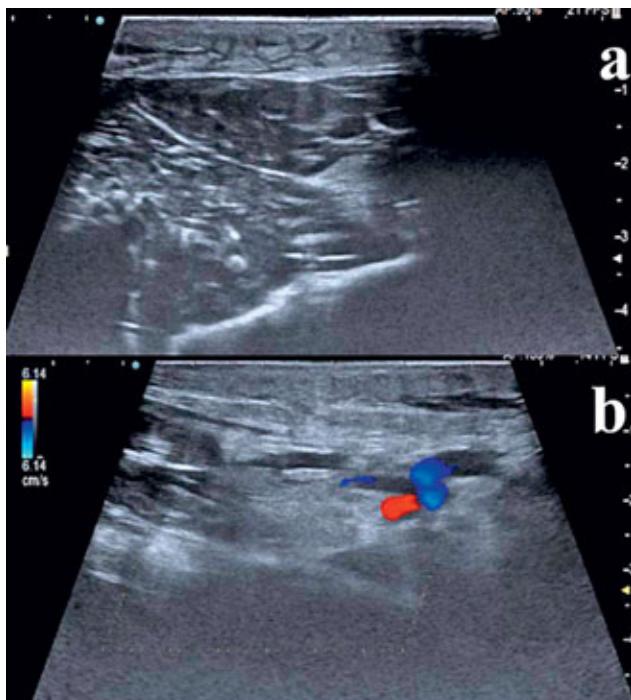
Duplex ultrasonography of deep veins of the left upper extremity, thrombosis of the axillary and the brachial vein are diagnosed.
